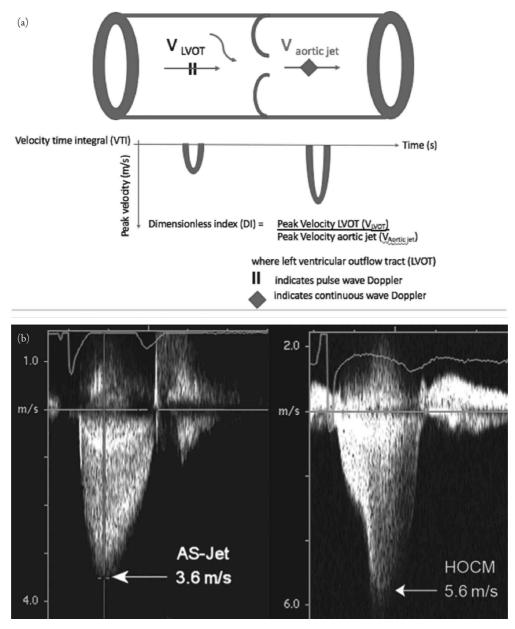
(a) Dimensionless index. (b) Aortic stenosis and sub-aortic stenosis jets. From Figure 3 of Baumgartner H, Hung J, Bermejo J, et al.; American Society of Echocardiography; European Association of Echocardiography. Echocardiographic assessment of valve stenosis: EAE/ASE recommendations for clinical practice. *J Am Soc Echocardiogr.* 2008;22(1):1–23.
